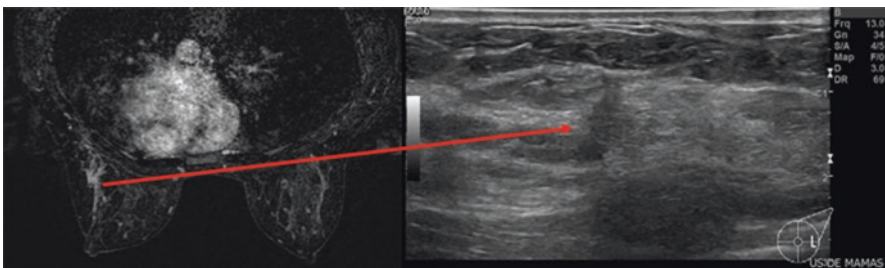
Non-mass enhancement associated with architectural distortion in the posterior third of the outer quadrants of the left breast in the mammary zone (surrounded by fibroglandular tissue) and its ultrasound correspondence (“second-look” ultrasound)
